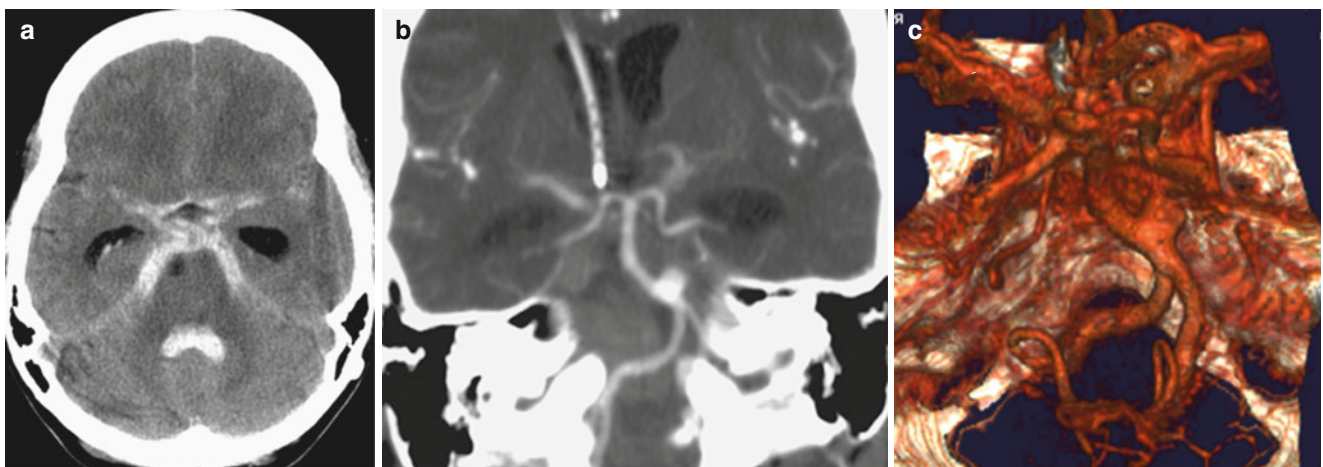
Subarachnoid hemorrhage due to basilar aneurysm. (a) Axial CT scan reveals acute blood in the basal cisterns and fourth ventricle. Temporal horn dilatation indicates hydrocephalus. (b, c) CT
